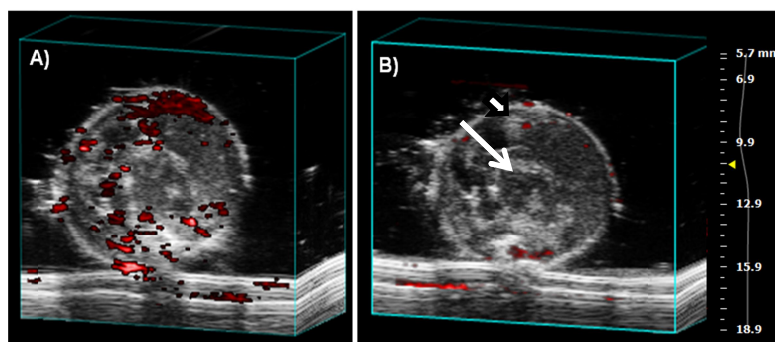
Images of xenograft prostate cancer (PC3) tumors, acquired (A) Before treatment and (B) Twenty four hours after treatment with US/1%MB+8Gy. Photoacoustic images are overlaid on top of the ultrasound B-mode images, block arrow points to the top of the tumor and the long arrow points to the bone of the leg. The yellow arrow on the side scale points to the focus.
